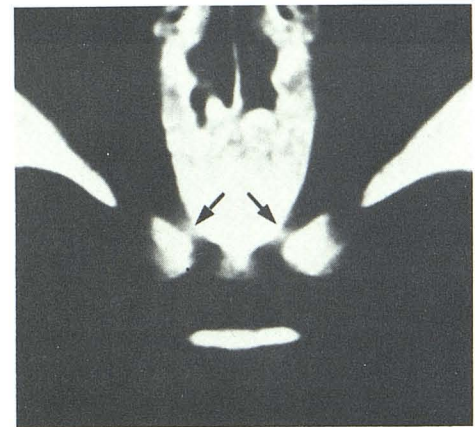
Thin-section axial CT scan at level of orbital apex demonstrating dense, thickened bony structures and suggesting evidence of encroachment on optic canals (arrows).
